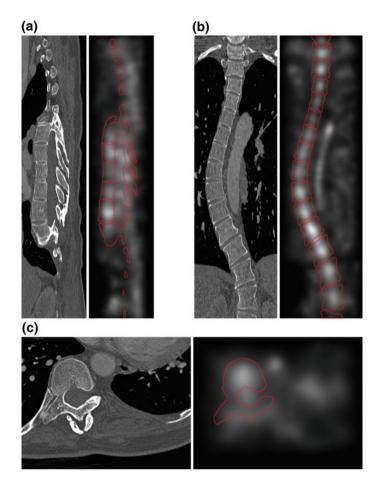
Original image *I* (*left*) and the corresponding accumulator A_I with superimposed spine boundaries (*right*), displayed for a selected a sagittal, b coronal and c axial cross-section of a 3D CT image of a scoliotic spine. In the accumulator A_I , *brighter elements* correspond to a larger number of intersections of lines connecting opposite edge points
